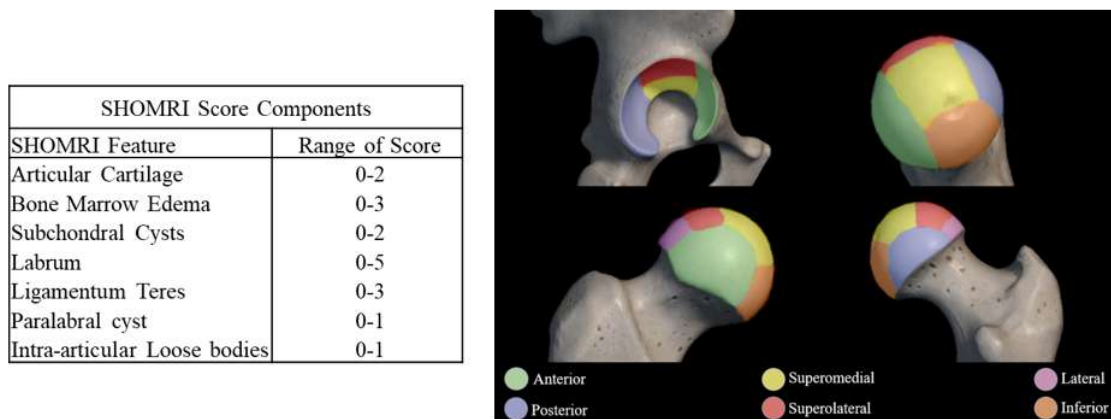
Scoring of Hip Osteoarthritis on MRI (SHOMRI) grading scale. The acetabulum is divided into 4 zones while the proximal femur is divided into 6 zones. Each zone is grade for each SHOMRI sub feature with a maximum score of 100.
